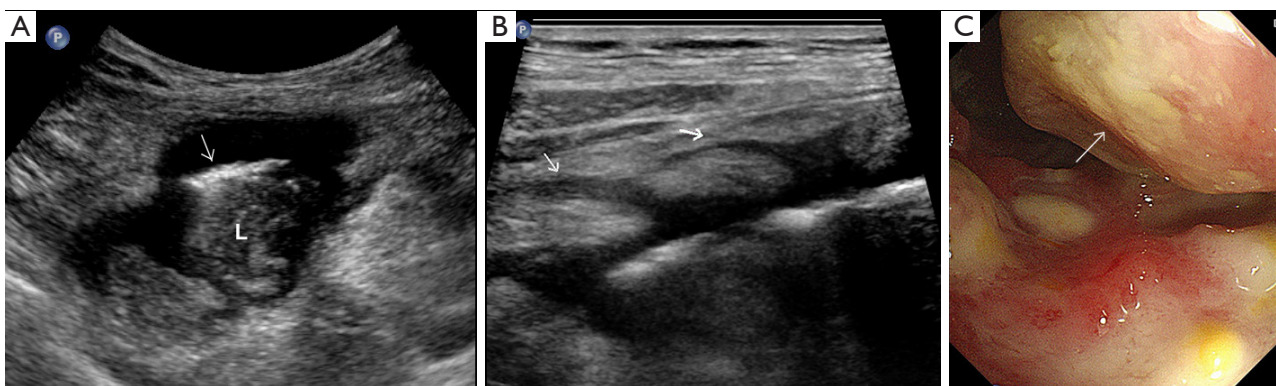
Representative intestinal ultrasound (IUS) images of intestinal Behçet's disease (BD). (A) Transverse view of the ileocecal region shows a large ulcer as a hyperechogenic line within the bowel wall with disappearance of the layered structure (arrow). (B) Longitudinal view of the same location showing the length of the ulcer and short fistulas (arrows). (C) Contemporaneous ileocolonoscopy also revealed a large ulcer in the same region (arrow). L, lumen.
